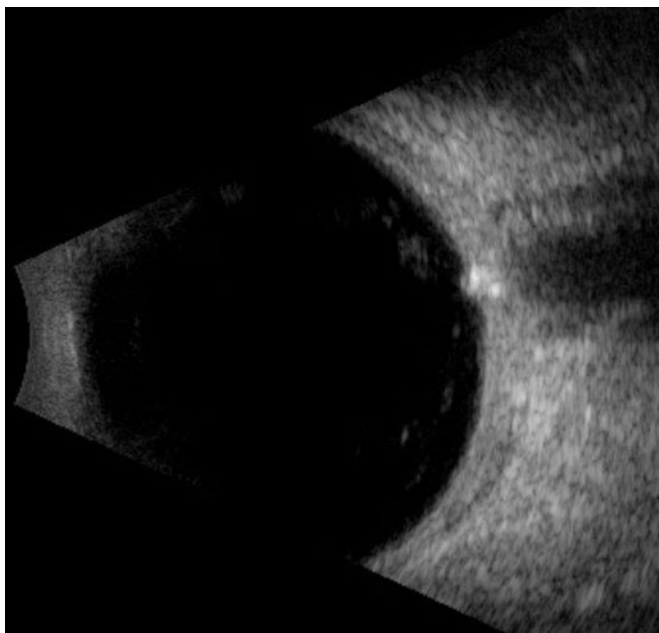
Hyper-reflective optic disc drusen in ultrasound.
